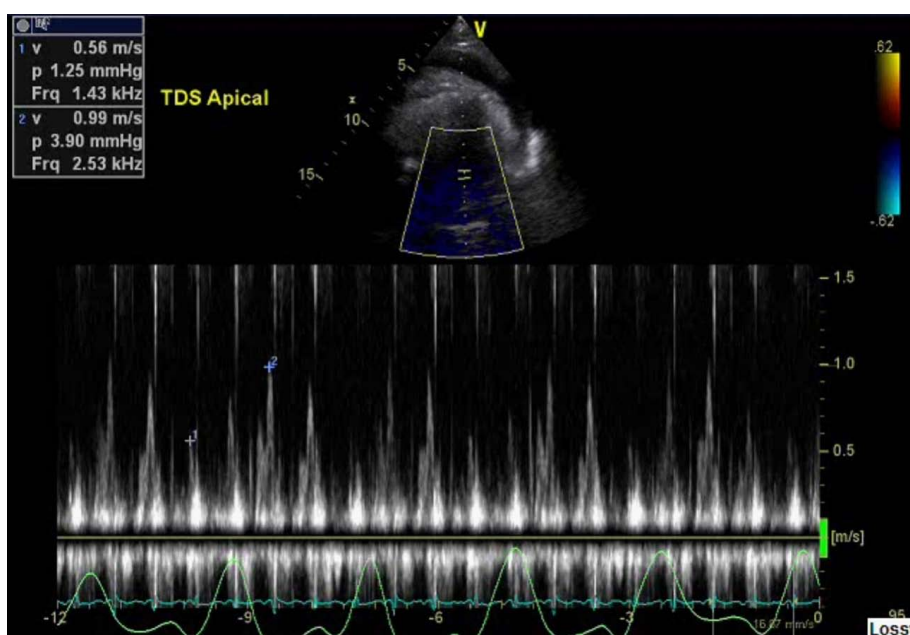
Transthoracic echocardiogram showing a mitral valve inflow E wave velocity greater than 25% respiratory variation suggestive of tamponade physiology.
